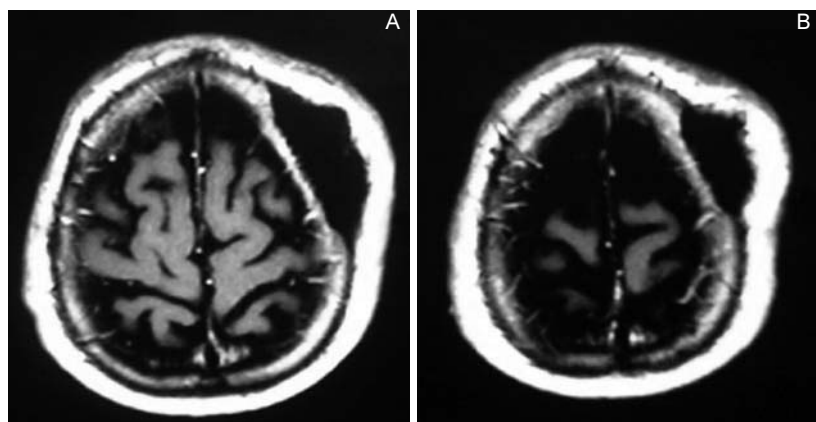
Osteoid osteoma, 75-year-old male with swelling of the front region. Axial T1-weighted gadolinium MRI.
